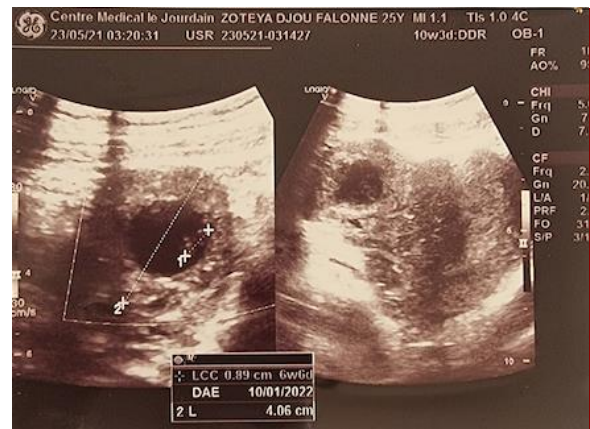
Ultrasonographic view
